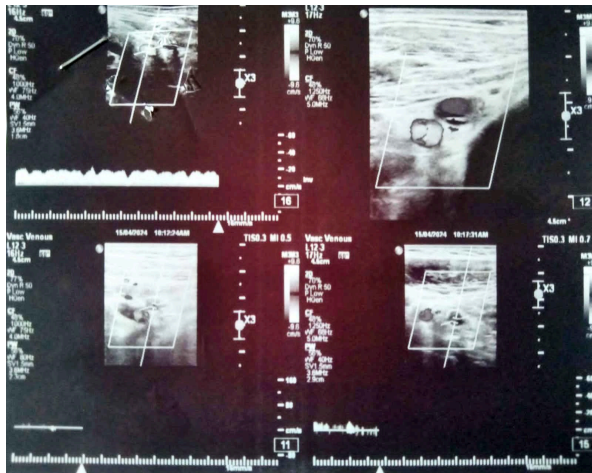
Venous Doppler study showing partial thrombosis after 1 month.
